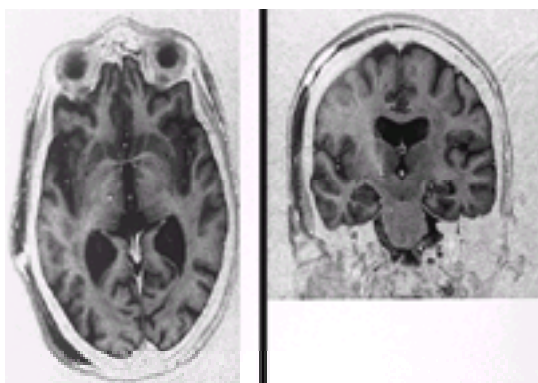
MRI obtained 1 day after the placement of a Medtronic quadripolar deep-brain stimulation electrode into the ventralis intermedius (Vim) of the thalamus for parkinsonian tremor. Fast spin echo inversion recovery sequence; TI, 200 ms; TR, 2000 ms; TE, 24 ms; slice thickness, 2.0 mm. (A) Axial scan at the level of the PC; (B) coronal scan 20 mm posterior to the AC. There is artefact around the lead, but its position in the ventral lateral thalamus 5 mm anterior to the PC can be seen.
